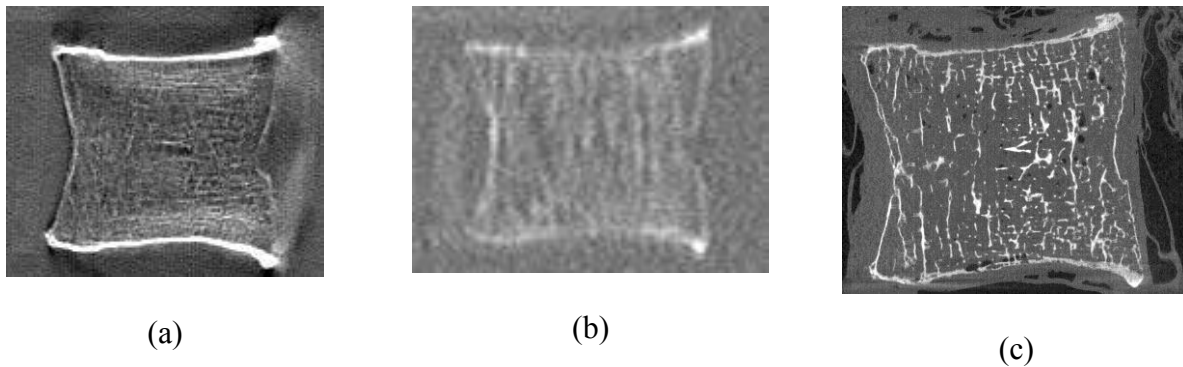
Comparison of images taken from sagittal plane in similar regions from (a) DTS, (b) HRCT, and (c) μ CT. Images are resized to show detail at comparable scale.
